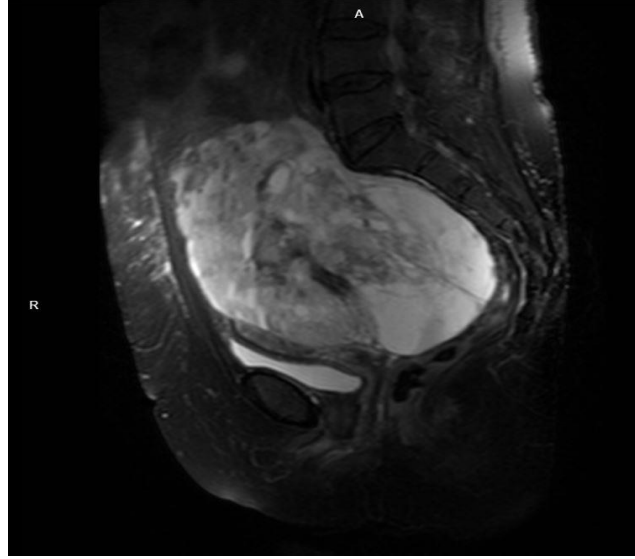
Magnetic resonance imaging shows a semisolid mass with 105x115x195 mm in diameter including cystic degenerated and calcified areas.
